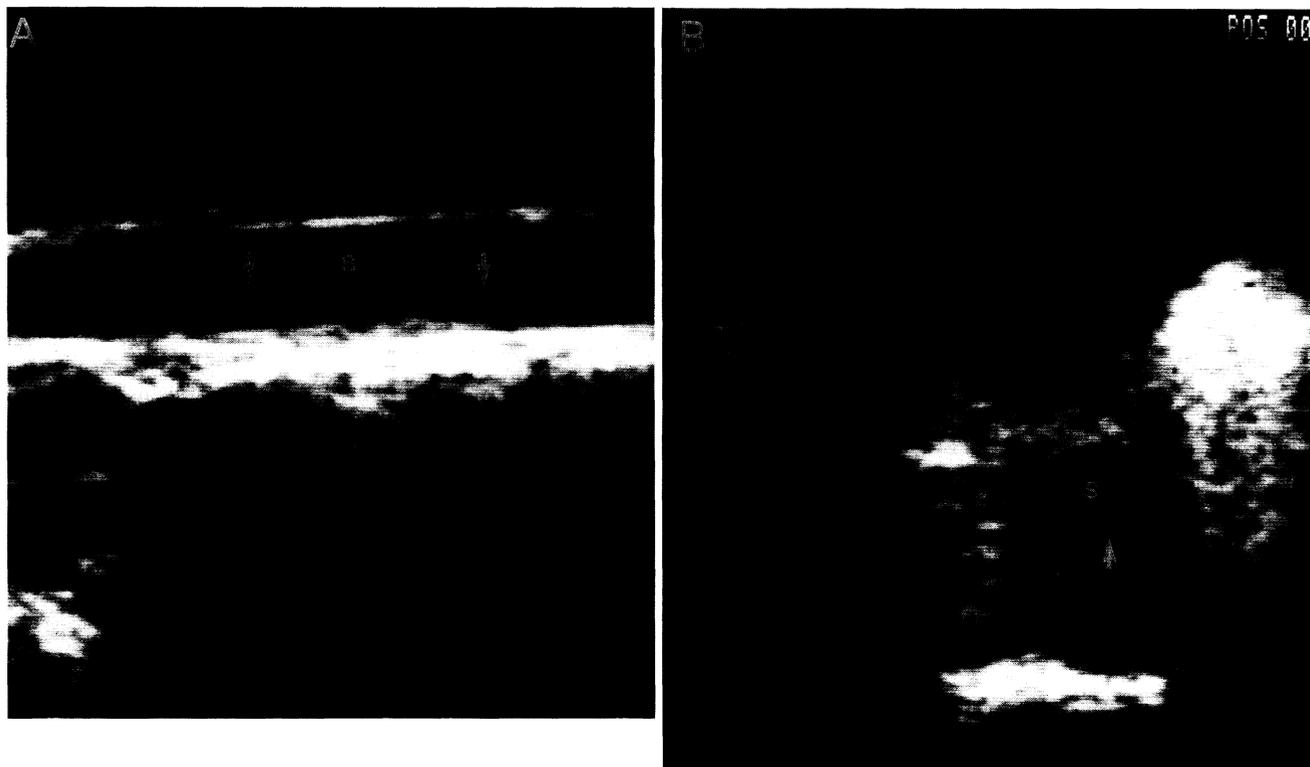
Longitudinal (A) and transverse (B) intraoperative sonograms of the normal spinal cord (S). The anterior and posterior margins of the cord and the central echo (arrows) are visible.
